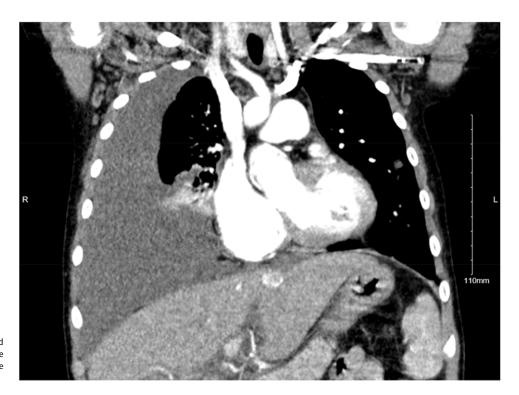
Chest CT coronal view obtained before chest tube placement showing a large right pleural effusion with right lower lobe capacity.
